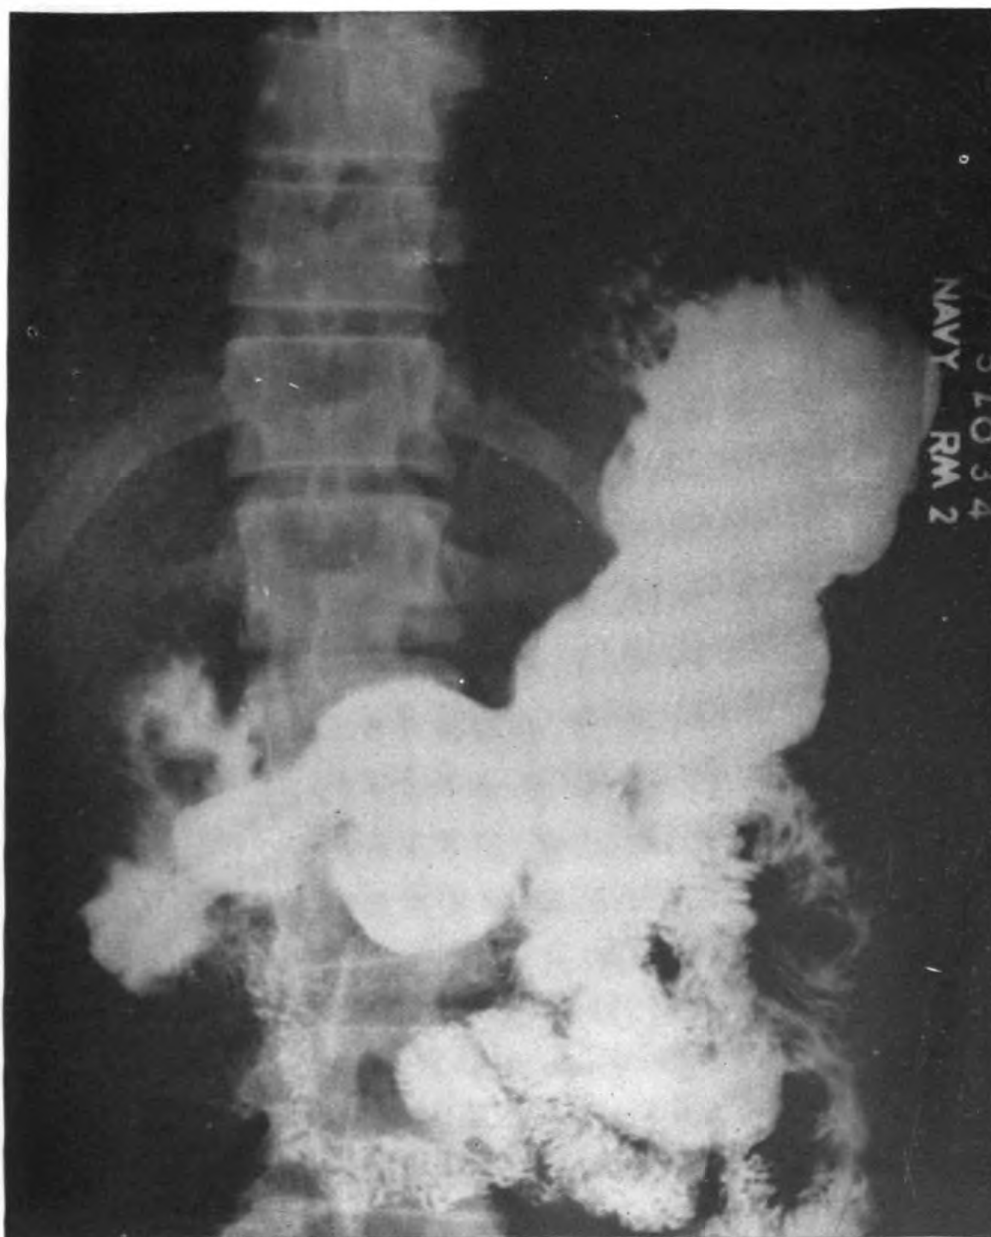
Roentgenogram shows pre-operative deformity of duodenum with crater formation.
